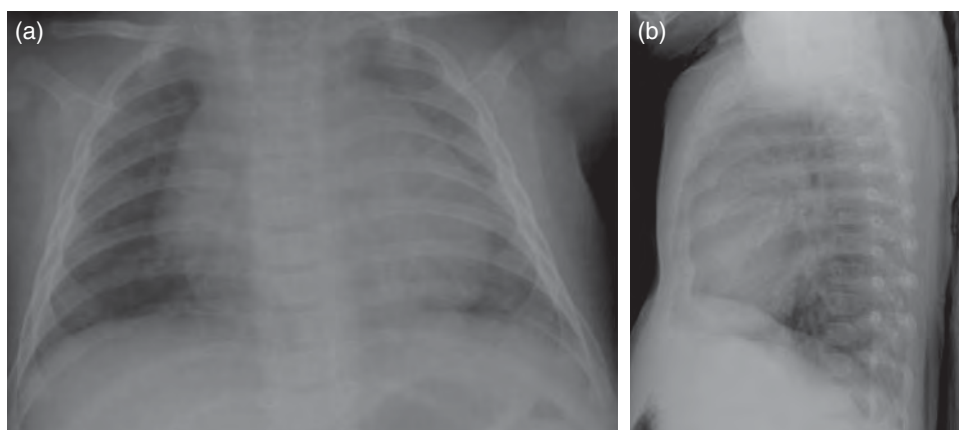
(a) Frontal and (b) lateral radiographs of the chest in an asymptomatic patient shows apparent cardiomegaly on the frontal view with a normal heart size on the lateral view. Thymic tissue in infants may make the cardiac silhouette appear enlarged.
